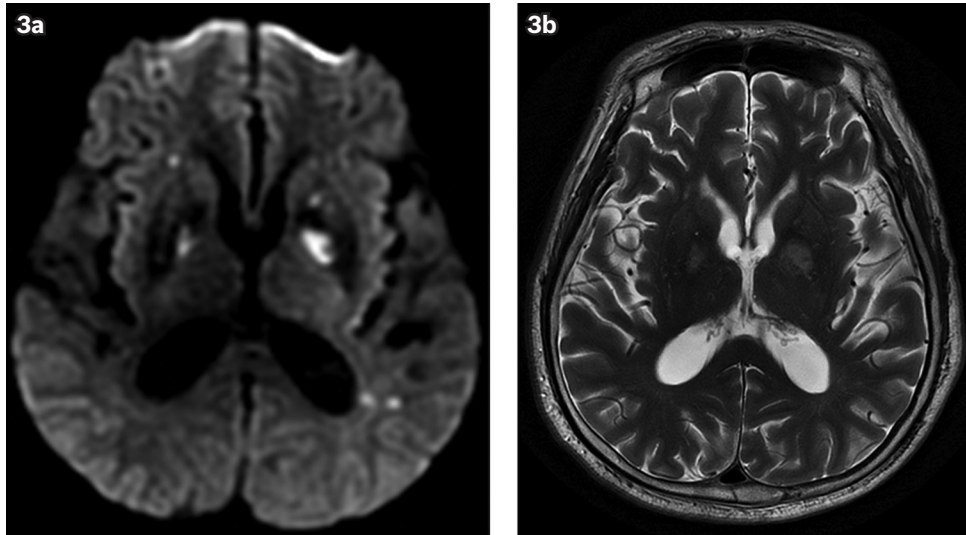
(a) DW and (b) T2-W MR images show bilateral symmetrical areas of T2 prolongation and restricted diffusion in the globi pallidi. The affected sites are best seen on the DW MR image.
